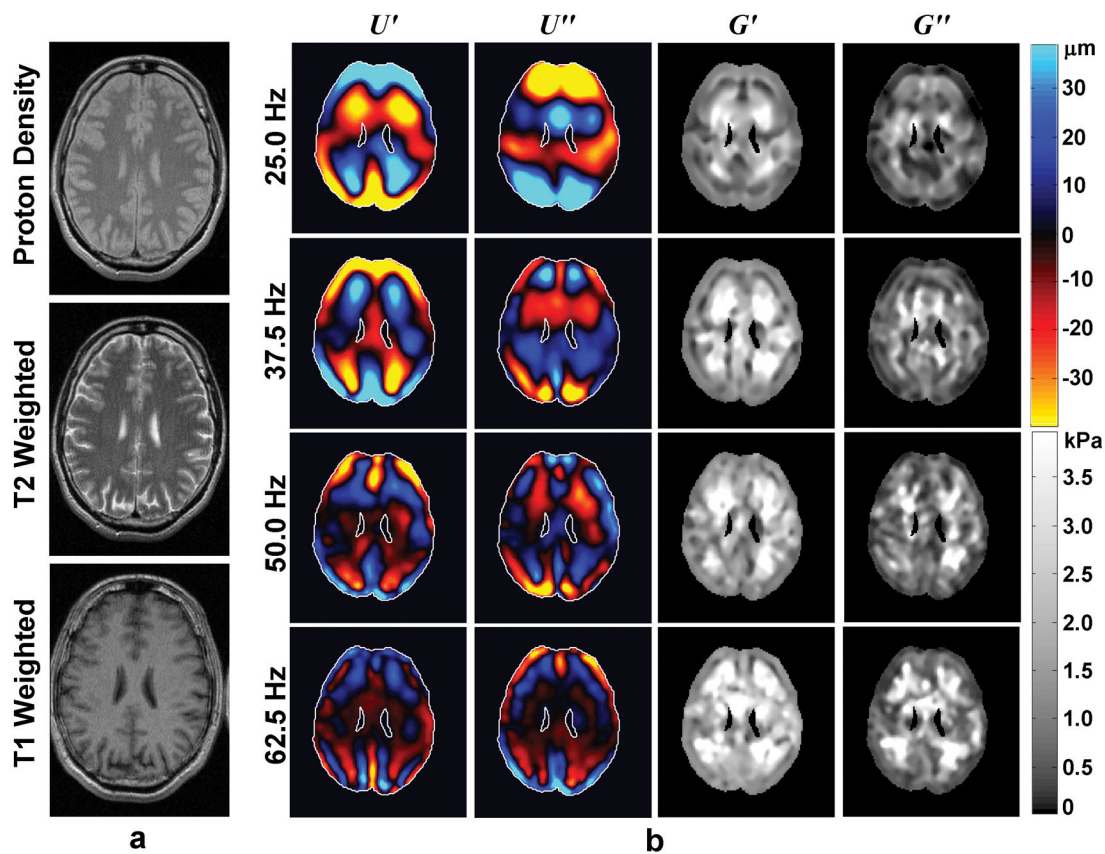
Example of brain MRE performed on a 47-year-old healthy male volunteer. (a) Proton-density-weighted, T2-weighted, and T1-weighted anatomical MR images. (b) Wave images and elastograms for data corresponding to several frequencies of mechanical vibration ranging from 25 Hz (top row) to 62.5 Hz (bottom row). The first two columns show the real and imaginary parts of the wave data obtained at each frequency, and the last two columns show the real and imaginary parts of the reconstructed shear moduli at each frequency. (From Sack I, Beierbach B, Wuerfel J, et al. The impact of aging and gender on brain viscoelasticity. *Neuroimage* 2009;46(3):652–657, adapted with permission.)
